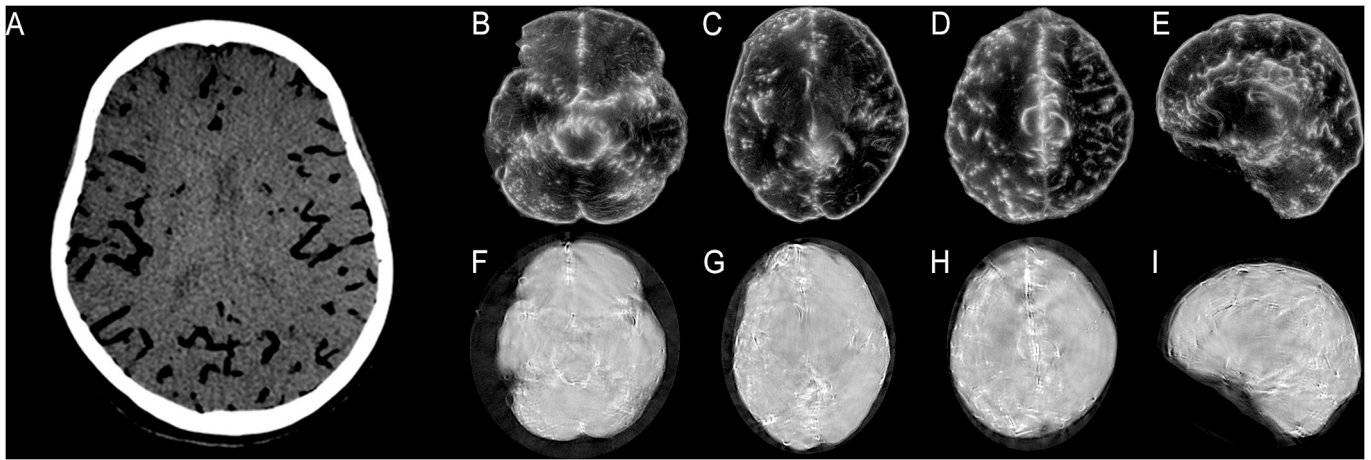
SoftVue Ultrasound Tomographic Imaging of a Brain Without a Skull. (A) Axial CT image of the cadaver brain through the level of the lateral ventricles. Axial reflection ultrasound tomographic imaging of the brain at the level of the midbrain (B), lateral ventricles/corona radiata (C), and centrum semiovale (D). (E) Sagittal reflection ultrasound tomographic image of the brain through the corpus callosum. Both axial and sagittal reflection imaging demonstrates key brain landmarks including sulci, gyri, interhemispheric fissure, choroid plexus, cerebellum, and brainstem. (F, G, H, I) Corresponding sound speed images to the reflection images.
